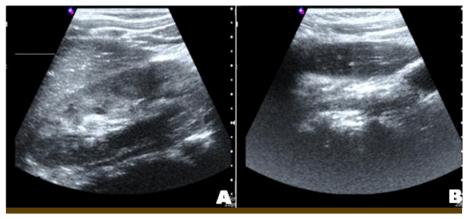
Ultrasonography showing normal left kidney measuring 7.3 cm (A) and absence of the right kidney in the renal space (B).
